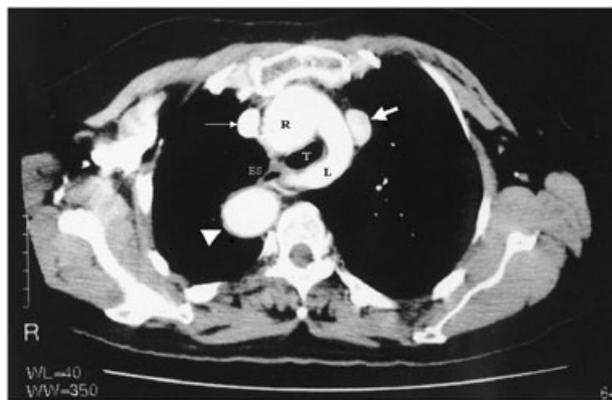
CT of thorax showing the double-arch aorta. Vessels are labelled clockwise from left to right: right-sided descending aorta (arrowhead), oesophagus (ES), right brachiocephalic vein (thin straight arrow), right aortic arch (R), left brachiocephalic vein (thick straight arrow), left aortic arch (L) and trachea (T).
